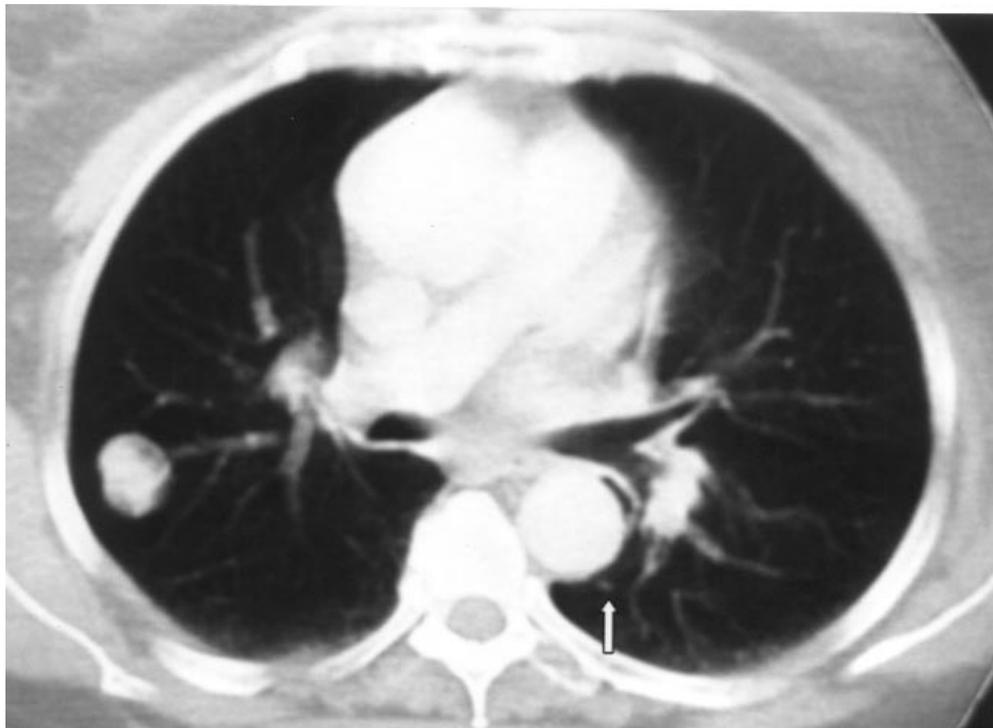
Thorax CT scan shows bilateral metastatic lesions in the lung.
